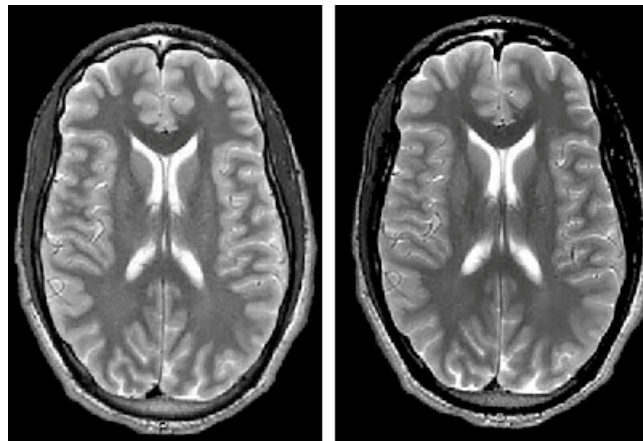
Axial representation of an MRI with Transversal relaxation time (T2) [5].
